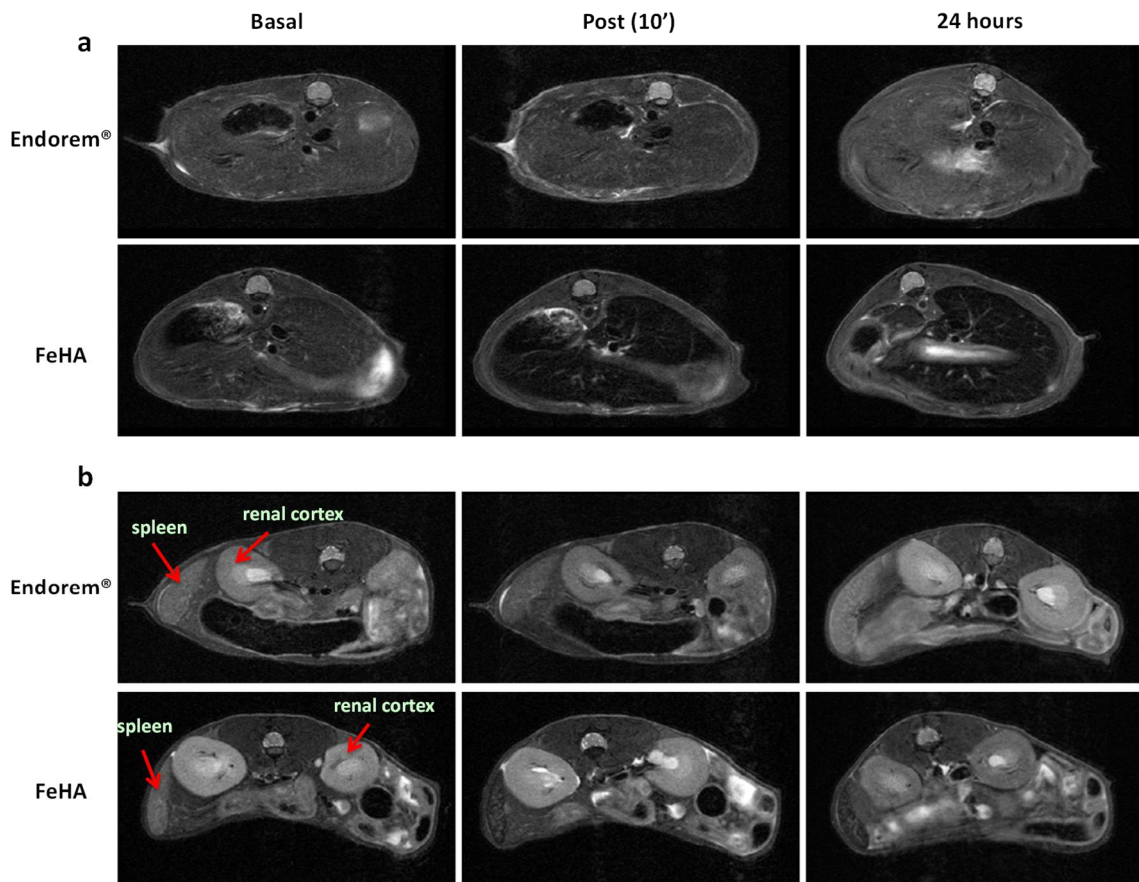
In vivo* RARE T2-weighted sequence, MRI images of liver (a), spleen and renal cortex (b) collected at different time points after intravenous administration of FeHA and Endorem® at a dose of 1.0 mg kg^{-1} .
